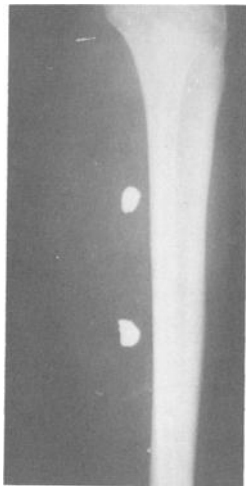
X-ray revealing fragmented projectile in muscle of leg.
